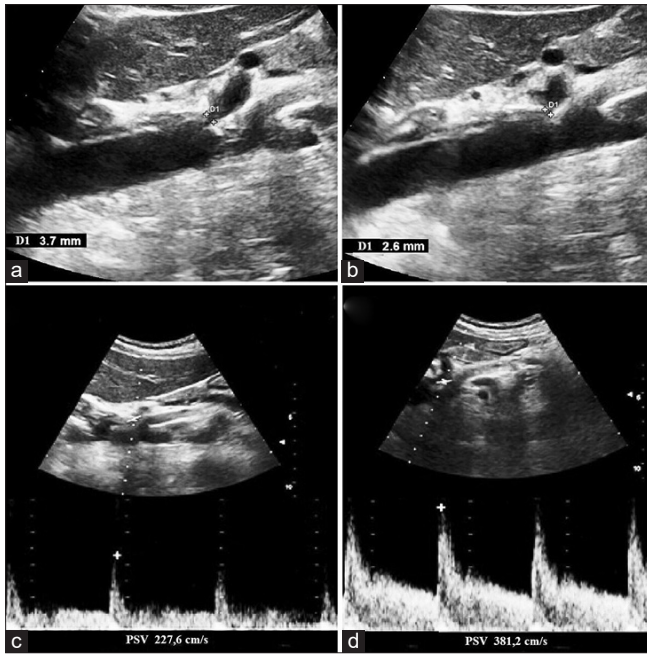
Ultrasound findings of DS. (a) Gray scale ultrasound of the CA, performed in inspiratory apnea, shows a stenosis at origin of CA (3, 7 mm in caliber), (b) which is accentuated in expiratory apnea (2, 6 mm). (c) The flow measurement of CA shows mild increase of peak speed velocity in inspiratory apnea (227,6 cm/s) and significantly increases in expiratory apnea (381,2 cm/s) (d). CA: Celiac artery
